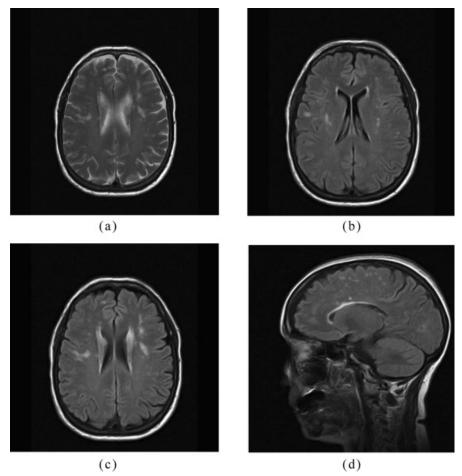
T-2 (a) and FLAIR-weighted images (b-d) in brain MRI showing hyperintense lesions in the white matter and in the grey-white matter border.
